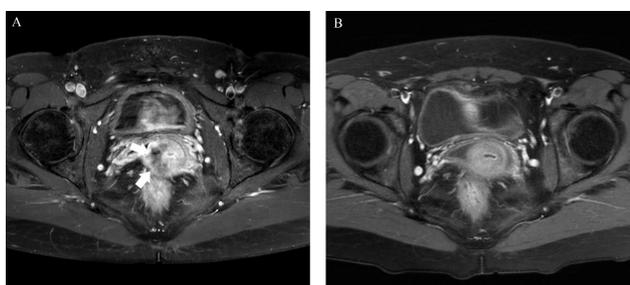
Axial T1-weighted fat suppressed magnetic resonance imaging of the pelvis; before (left) and after (right) the NACT showing near complete resolution of the lesion.
